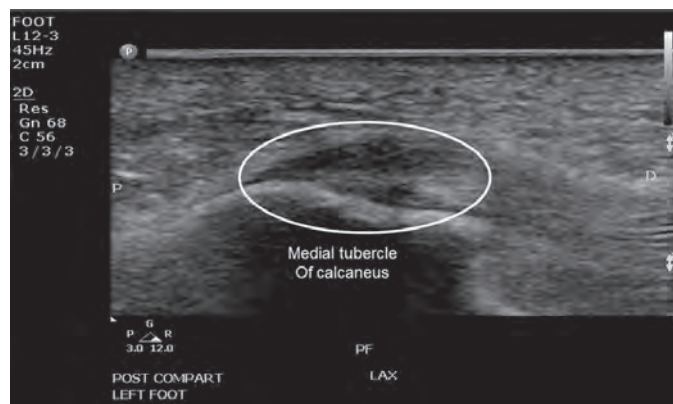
Ultrasound image of plantar fasciitis showing thickening and a hypoechoic area at the insertion of the plantar fascia at the site of the medial tubercle of the calcaneus.
